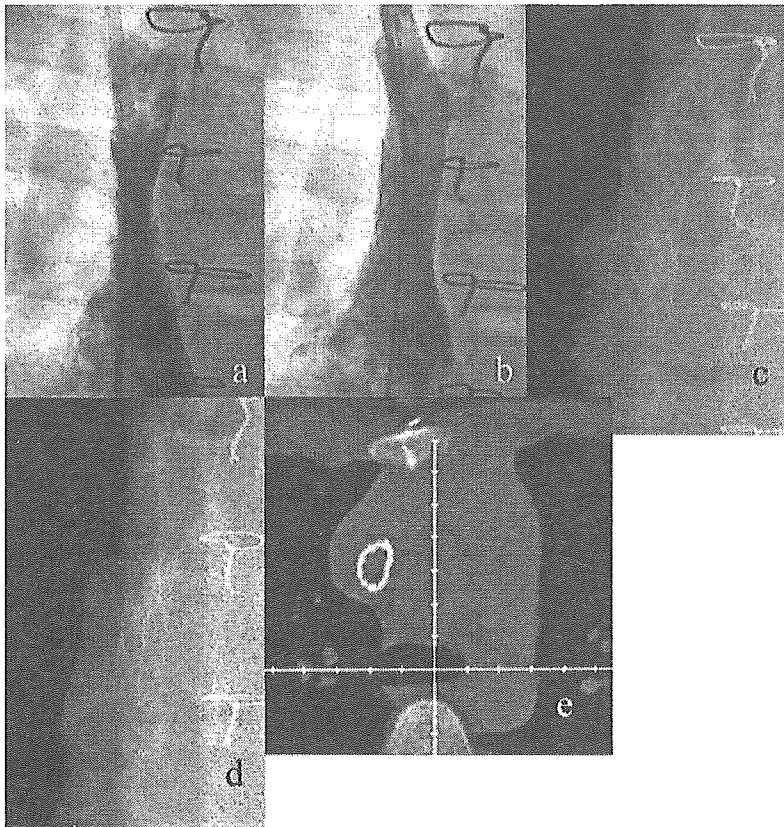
Angiogram of superior vena cava before (a) and after (b) implantation of a P308 stent in case 2. Chest X-ray just (c) and 27 months (d) after stent implantation. Longitudinal compression was observed on chest X-ray at 27 months. e: CAT scan showed semicircular cross-section of the stent with flattening of the side adjacent to ascending aorta.
